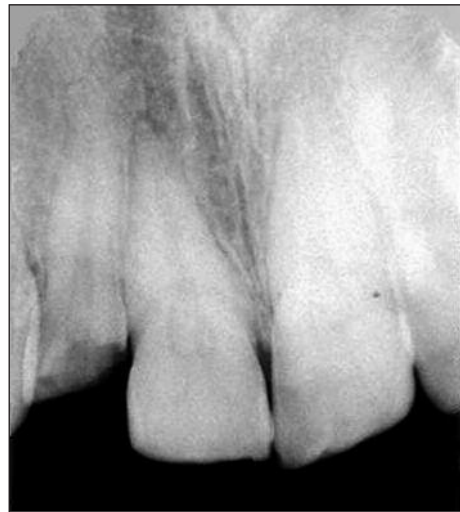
The radiographic image of the tooth after trauma.
